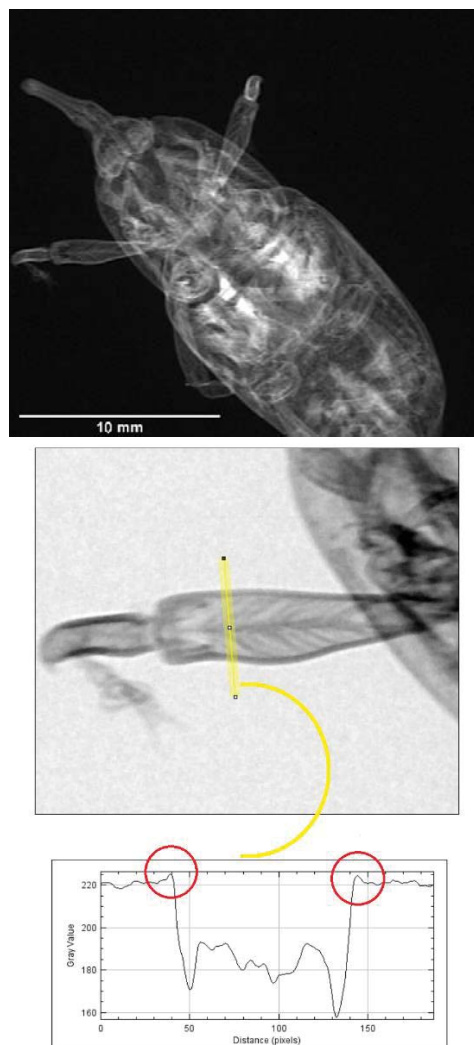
(Top) Phase contrast radiography of a beetle “red palm weevil” (*Rhynchophorus ferrugineus*), taken at 80 kV with a microfocus X-ray tube (7 μm focal spot size) with a magnification $M \cong 4$, $R_1 \cong 250$ mm, $R_2 \cong 750$ mm. (Bottom) Detail of the left-side leg: a line profile across the leg shows some edge enhancement effect (overshoots circled in the line profile plot).
